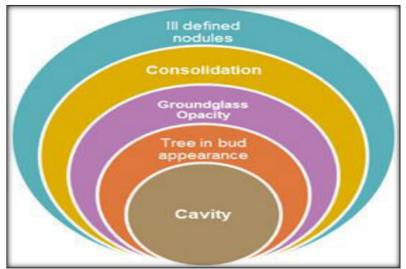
HRCT patterns of active tuberculosis
